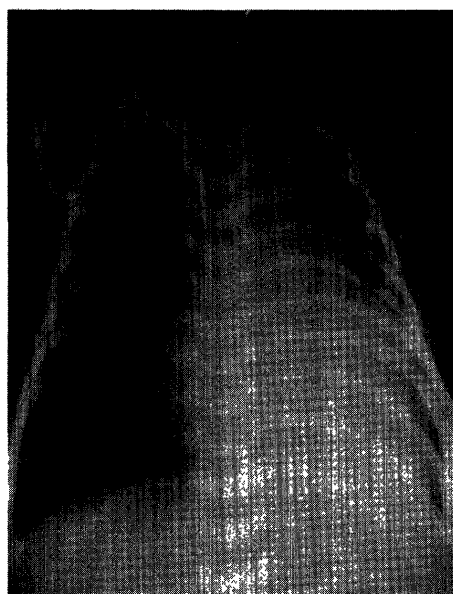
Chest radiograph on day 6 showing markedly improved cardiac failure (cardiothoracic ratio of 62%).
